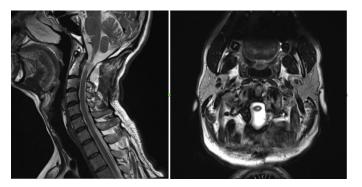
1st patient post-operative 4th year MRI MRI: Magnetic resonance imaging
